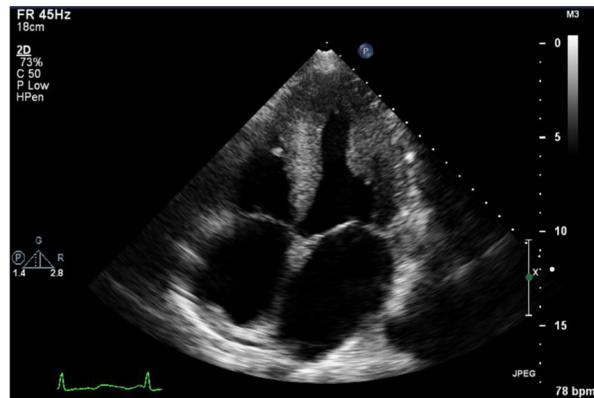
A four-chamber apical view echocardiogram showing bi-atrial dilatation, valve thickening, thick ventricular walls, and interventricular septum with speckled appearance.
